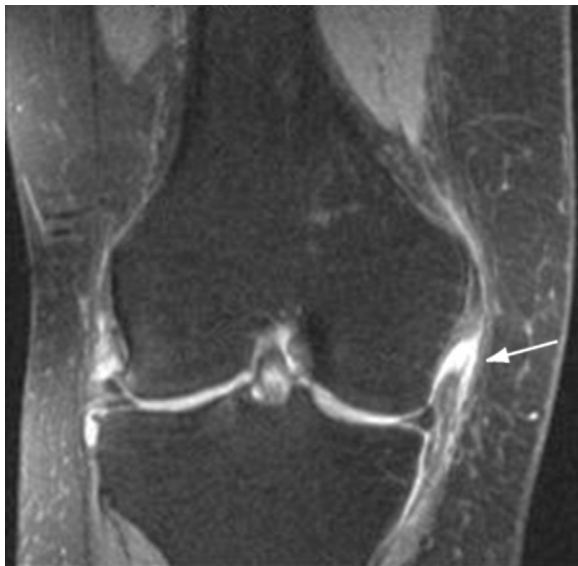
Coronal magnetic resonance imaging sequence showing full-thickness injury to the medial collateral ligament at its femoral attachment site. (Reprinted with permission from Cole B. *Surgical Techniques of the Shoulder, Elbow, and Knee in Sports Medicine*. Philadelphia: Saunders, 2008. Fig. 70-3.)
